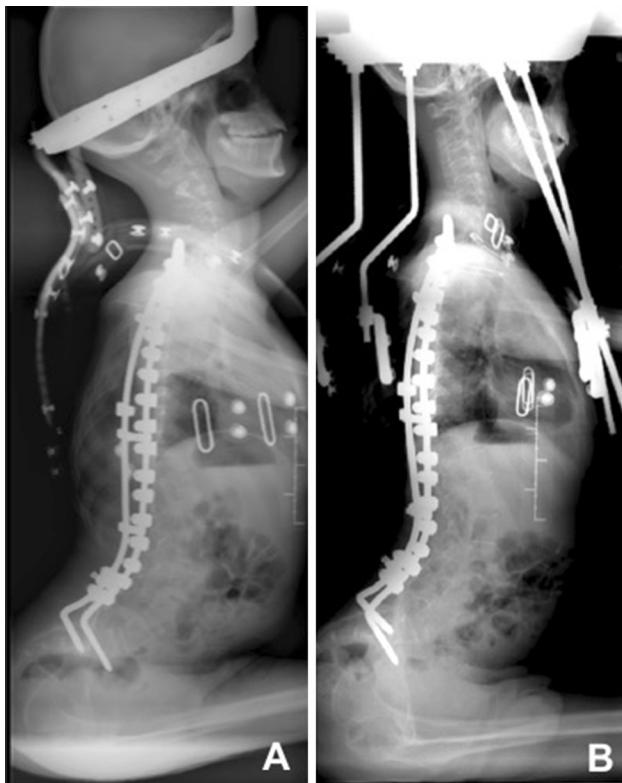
Radiography, lateral view of the whole spine (see the correction of cervical hyperlordosis). a Day zero of the halo installation. b 6 months later
